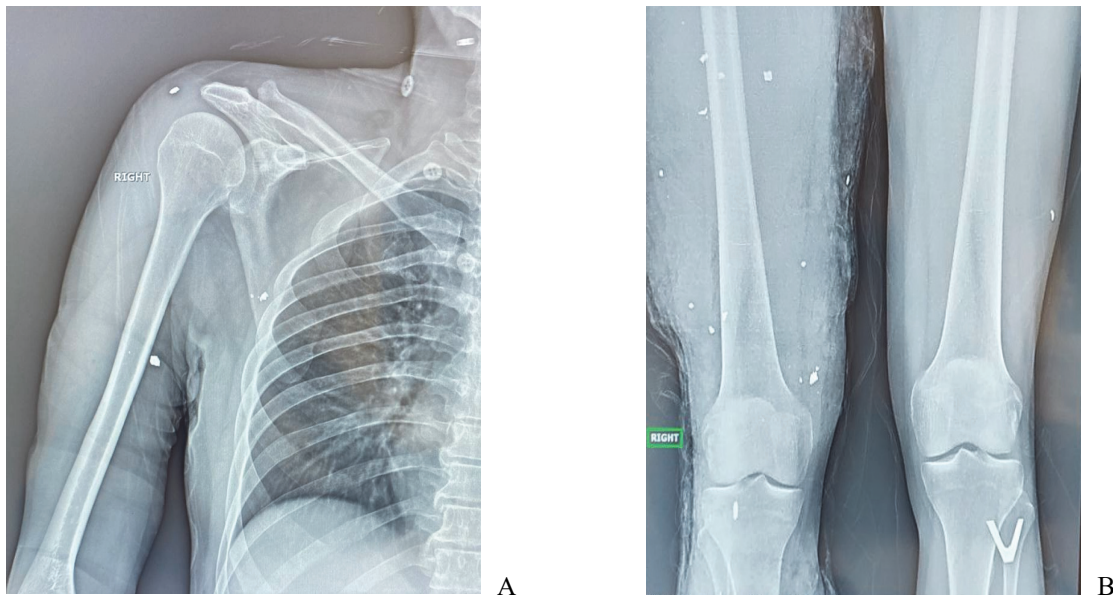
X-ray examination data of the wounded K., 46 years: A – X-ray of the right half of the chest, shoulder and neck on the right, direct projection. Numerous foreign bodies in the soft tissues are identified; B – X-ray of the hips, direct projection. Numerous foreign bodies in the soft tissues are identified.
